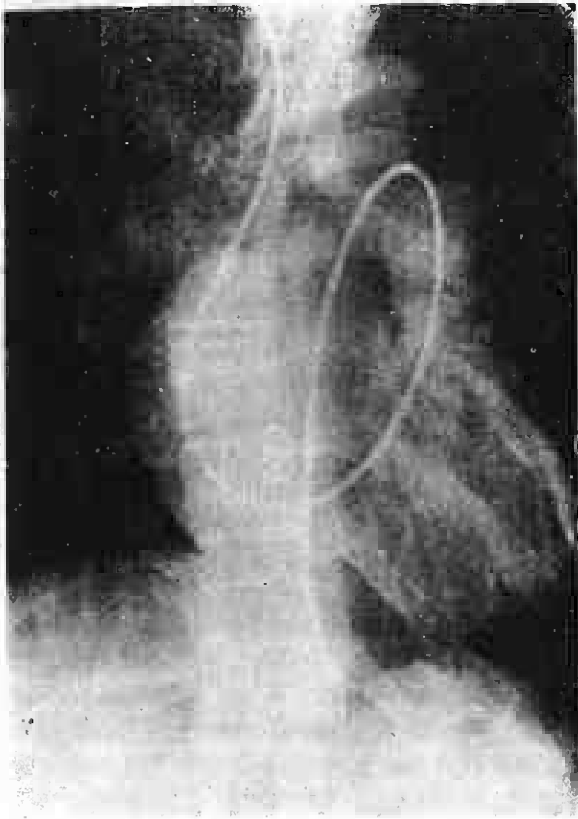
X-ray chest in a case of Patent ductus arteriosus showing the catheter tip in the Aorta from the Pulmonary Artery through the patent ductus.
